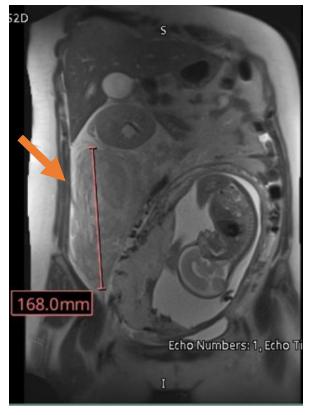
MRI of pelvis showing retroperitoneal hematoma as shown by arrow.
